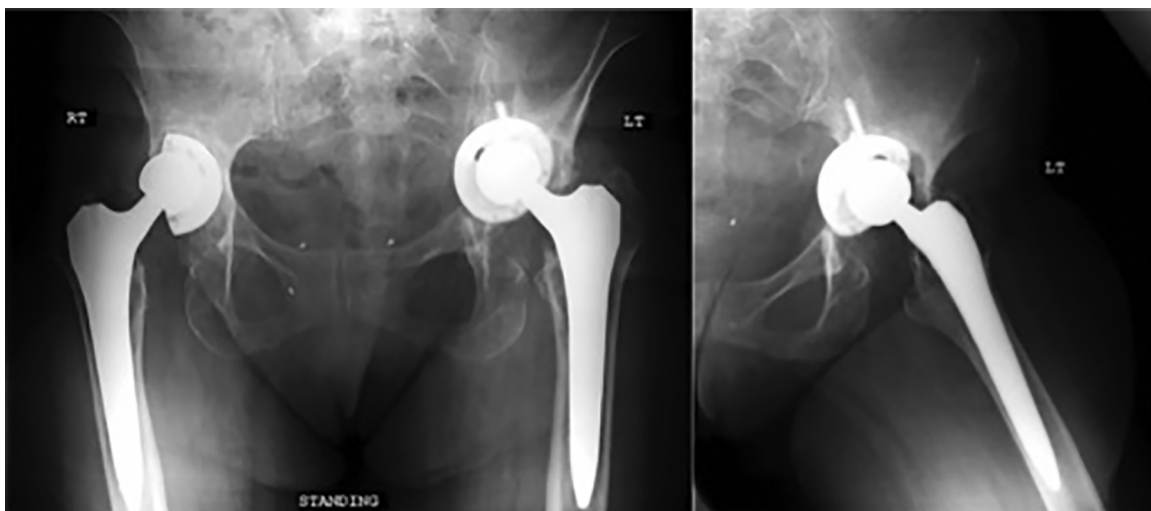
Pelvic AP radiograph and Frog-lateral of the left hip 33 months status post bilateral primary THA. There is further loosening of the right acetabular component with an inclination of almost 90° and medial migration of the acetabular cup. Further left sided acetabular component migration with intra-pelvic protrusion and suspected pelvic discontinuity.
